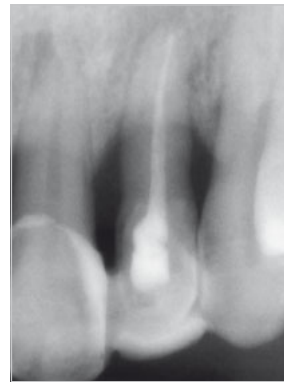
Radiograph of the transplanted maxillary left lateral incisor taken 8 years postoperatively. There is clear vertical bone gain and no evidence of advanced root resorption.
